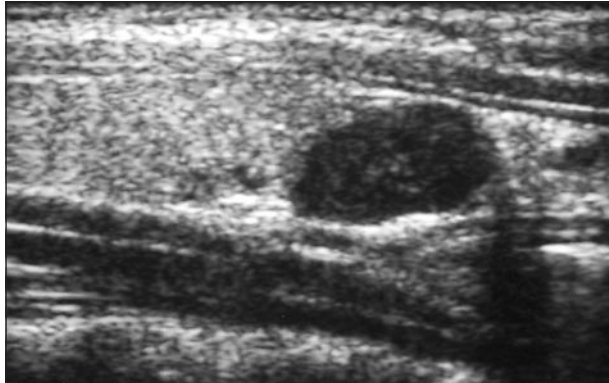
An ultrasound view of a 400-mg adenoma in an 11-year-old girl who presented with pancreatitis, renal stones, lethargy, and weight loss.
